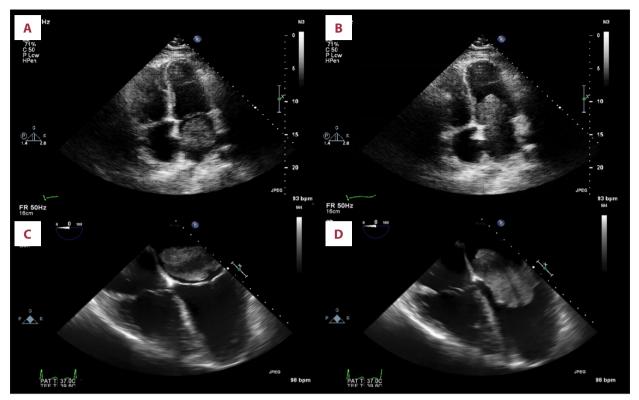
(A, B) Initial transthoracic echocardiogram demonstrating a large left atrial mass (9×4 cm) prolapsing into the left ventricle. Right ventricular systolic pressure was 95 mmHg. (C, D) Perioperative transesophageal echocardiogram demonstrating a 7.5×4.5 cm mass attached to the atrial septum. Left ventricular ejection fraction was 40-45%.
